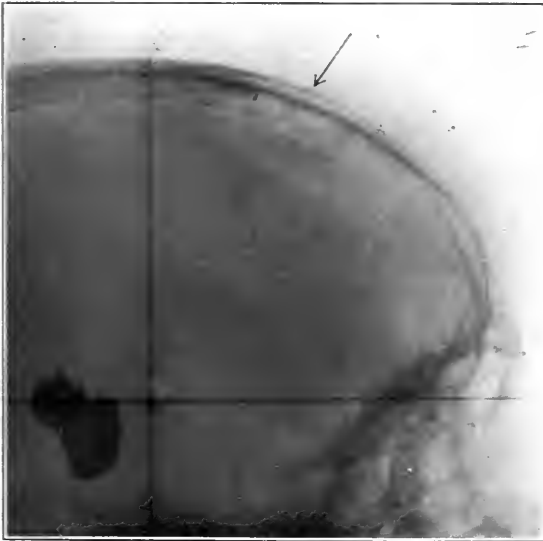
Case 82. X-ray photograph showing deep position of large missile, and characteristic track.
